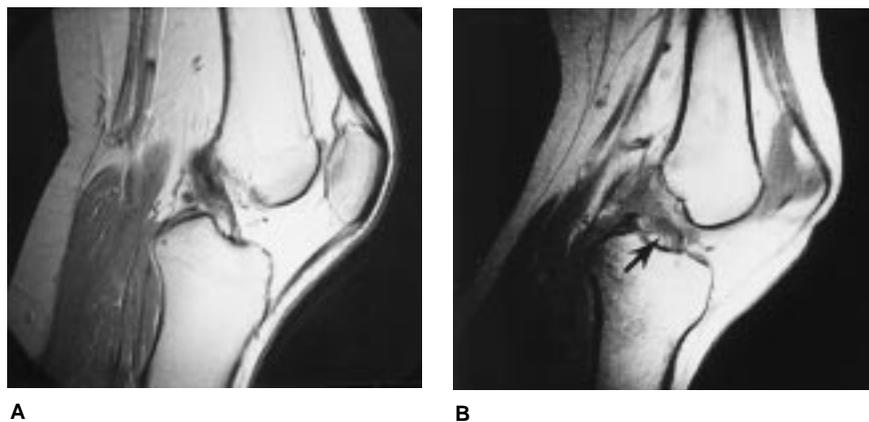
Magnetic resonance images of a normal (A) and an abnormal (B) ACL (arrow).
